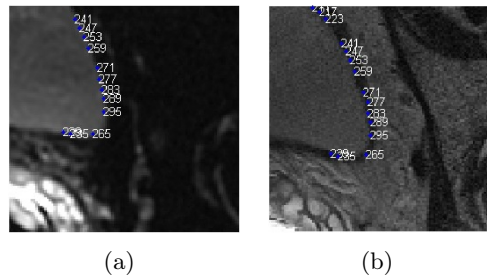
Some of the bladder border points matched with ICP on DWI (a) and T2-w (b) images.*
